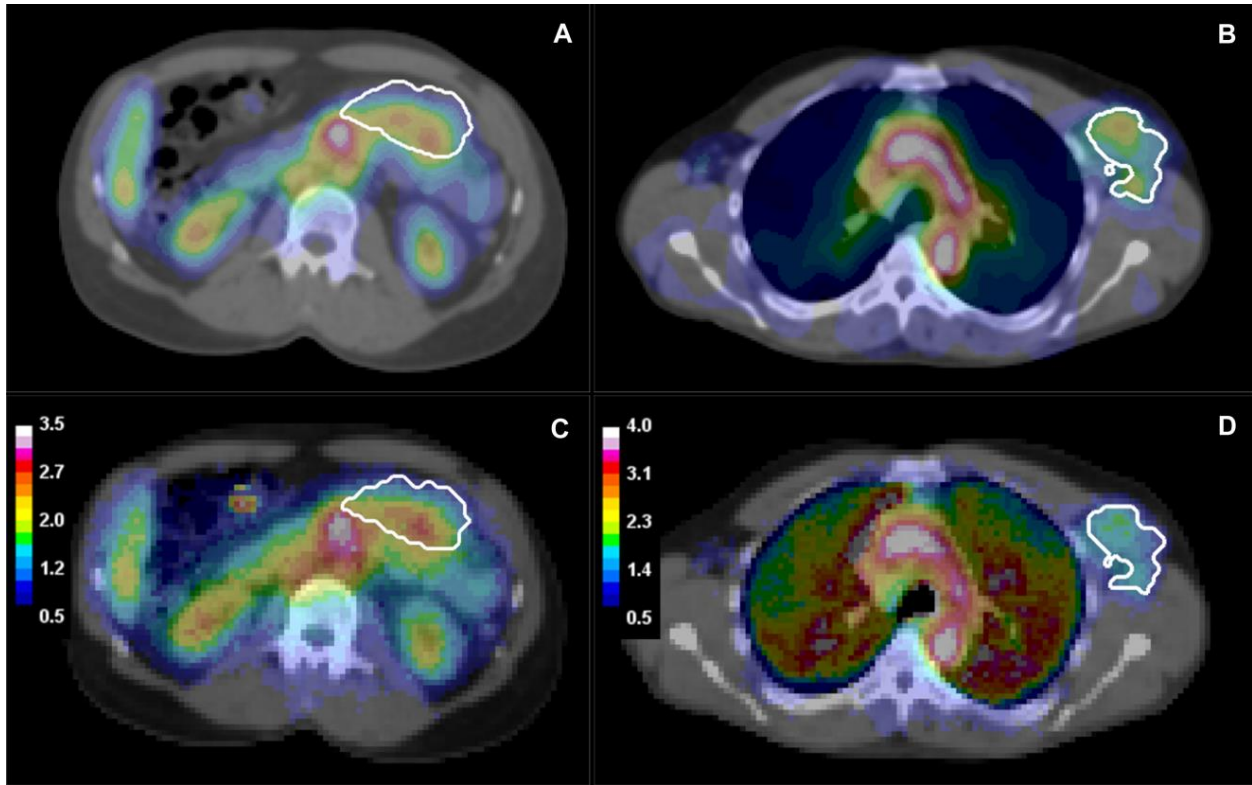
Fused SPECT/CT images for (a) Patient 1 and (b) Patient 2 with matching 3D dose maps overlaid on CT for (c) Patient 1 and (d) Patient 2. Dose maps are displayed in Gy.
